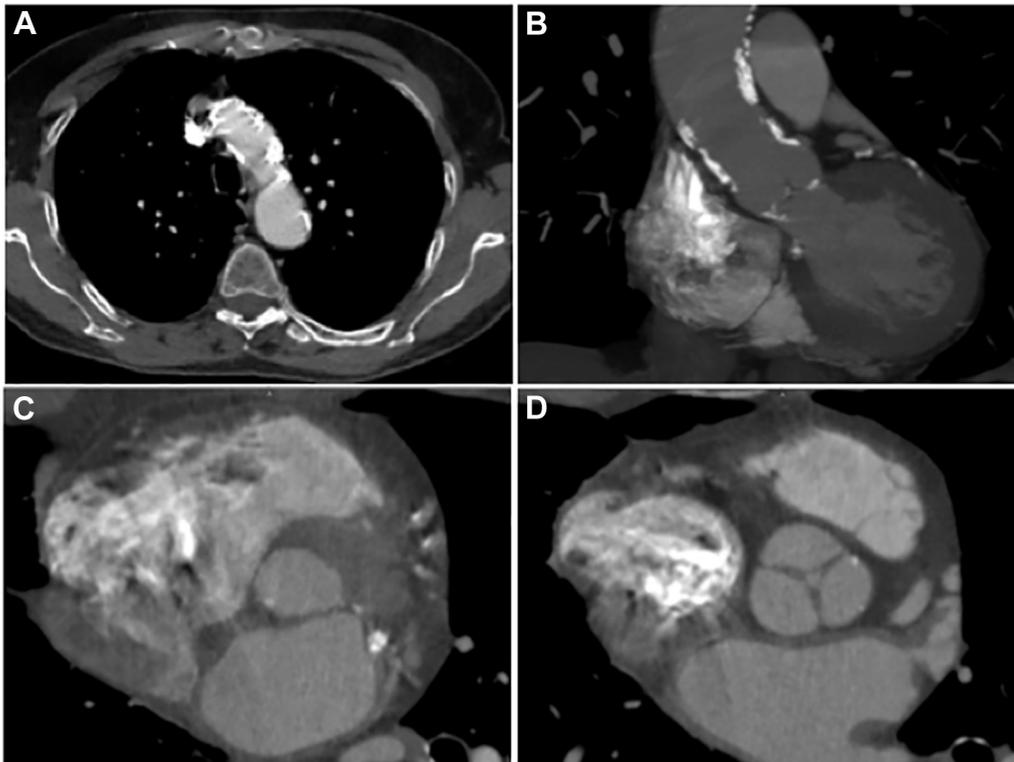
Computed tomography scan evaluation of the ascending aorta and of the aortic valve. (A, B) Evaluation of the ascending aorta: the main finding is severe calcific atherosclerotic disease (porcelain aorta) that precludes conventional open heart surgery. (C, D) Evaluation of the aortic valve and virtual basal ring. The annular perimeter was 67 mm, whereas the area was 342 mm²; the perimeter-derived diameter was 21.3 mm.
